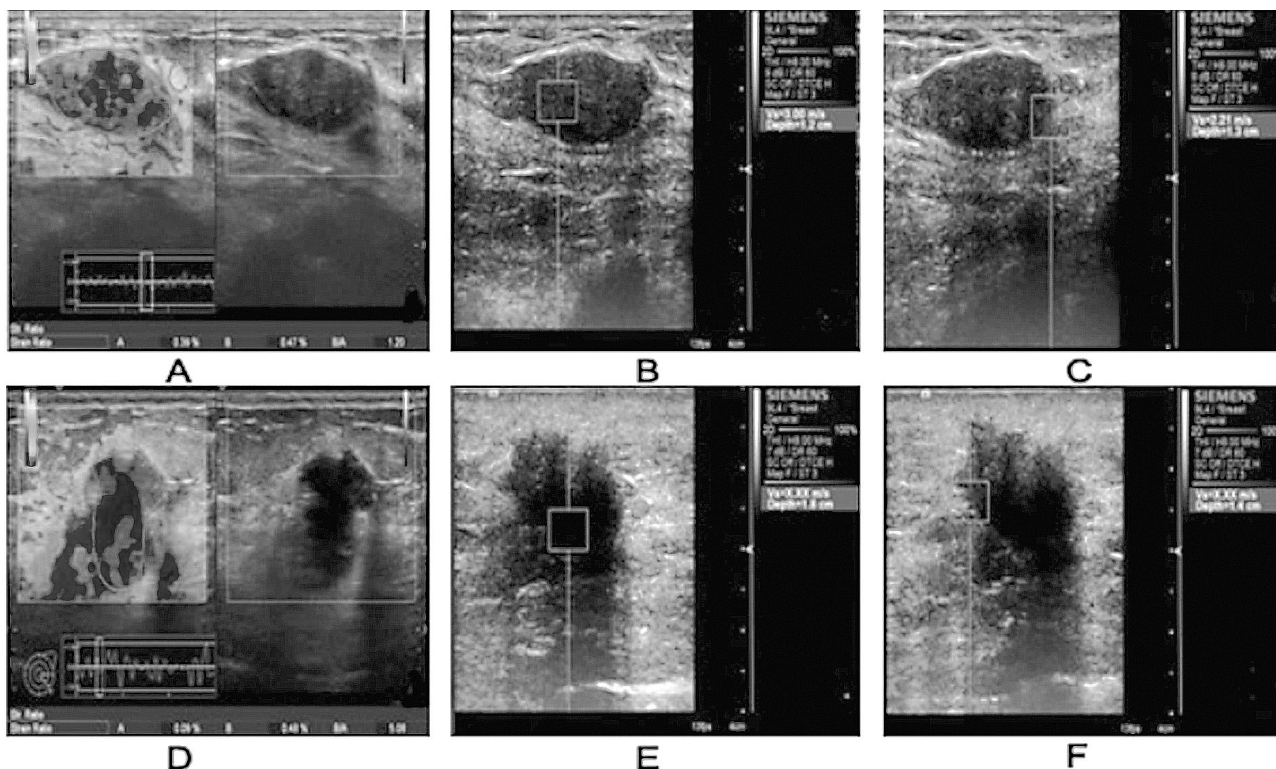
Two hypoechoic masses on ultrasonography, which are benign (A, B, and C) and invasive ductal carcinoma (E, F, and G) by postoperative pathologic results, respectively. (A) RTE elasticity score is 3 and SR is 1.20. (B) The internal SWV value is 2.85 m/s. (C) The marginal SWV value is 2.37 m/s. (E) RTE elasticity score is 4 and the SR is 5.06. (F) The internal SWV value is X.XX m/s. (G) The marginal SWV value is X.XX m/s.
